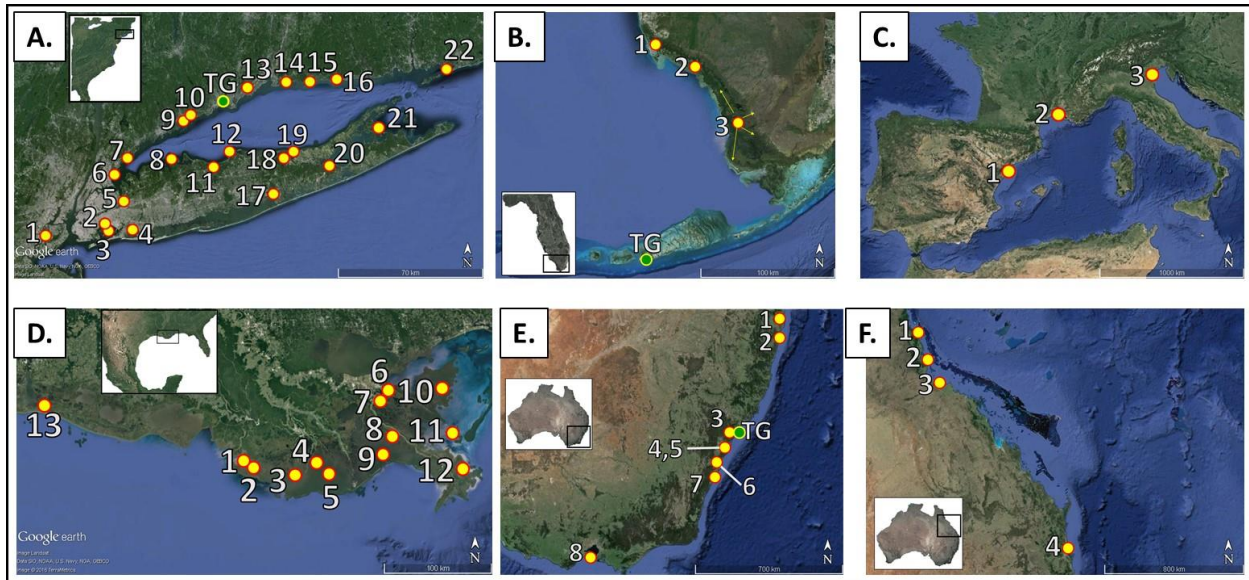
Location of regions examined in this study. Numbered place markers indicate locations of specific wetlands/ sub-regions where data was recorded from the literature. Green and yellow place markers indicate locations of tide gauges (TG) used for sea level comparisons. Locations in the maps are as follows: A) New York & Connecticut, USA: 1. Staten Island, NY, 2. Jamaica Bay, NY, 3. Hempstead Bay, 4. Alley Pond, NY, 5. Pelham Bay, NY, 6. Otter Creek, NY, 7. Marshlands Conservancy, Rye, NY, 8. Caumsett State Park, NY, 9. Norwalk, CT, 10. Westport, CT, 11. Nissequogue River, NY, 12. Flax Pond, NY, 13. Millford, CT, 14. Branford, CT, 15. Guilford, CT, 16. Clinton, CT, 17. Carmans River, NY, 18. Deep Pond, NY, 19. Fresh Pond, NY, 20. Hubbard County Park, NY, 21. Mashomack Preserve, NY, 22. Barn Island, CT, & Tide Gauge: Bridgeport, CT. B) Southwest Florida, USA: 1. Rookery Bay, 2. Ten Thousand Islands, 3. Southwest Everglades National Park, & Tide Gauge: Key West. C) Northwestern Mediterranean Sea: 1. Ebro River Delta, Spain, 2. Rhone River Delta, France, & 3. Venice Lagoon, Italy. D) Louisiana, USA: 1. Fourleague Bay, 2. Old Oyster Bayou, 3. Terrebonne, 4. Bayou Chitigue, 5. Lake Barre, 6. Violet, 7. Caernarvon, 8. West Point a la Hache, 9. Barataria Bay, 10. St. Bernard, 11. Breton Sound, 12. Delta National Wildlife Refuge, & 13. Cameron Parish. E) Southeast Australia: 1. Tweed River, 2. Evans Head, 3. Hunter River, 4. Parramatta River, 5. Sydney, 6. Minnamurra River, 7. Jervis Bay, 8. Western Port Bay, & Tide Gauge: New Castle V. & F) Northeast Australia: 1. Cairns, 2. Missionary Bay & Hinchinbrook Channel, 3. Magnetic Island, & 4. Moreton Bay.
